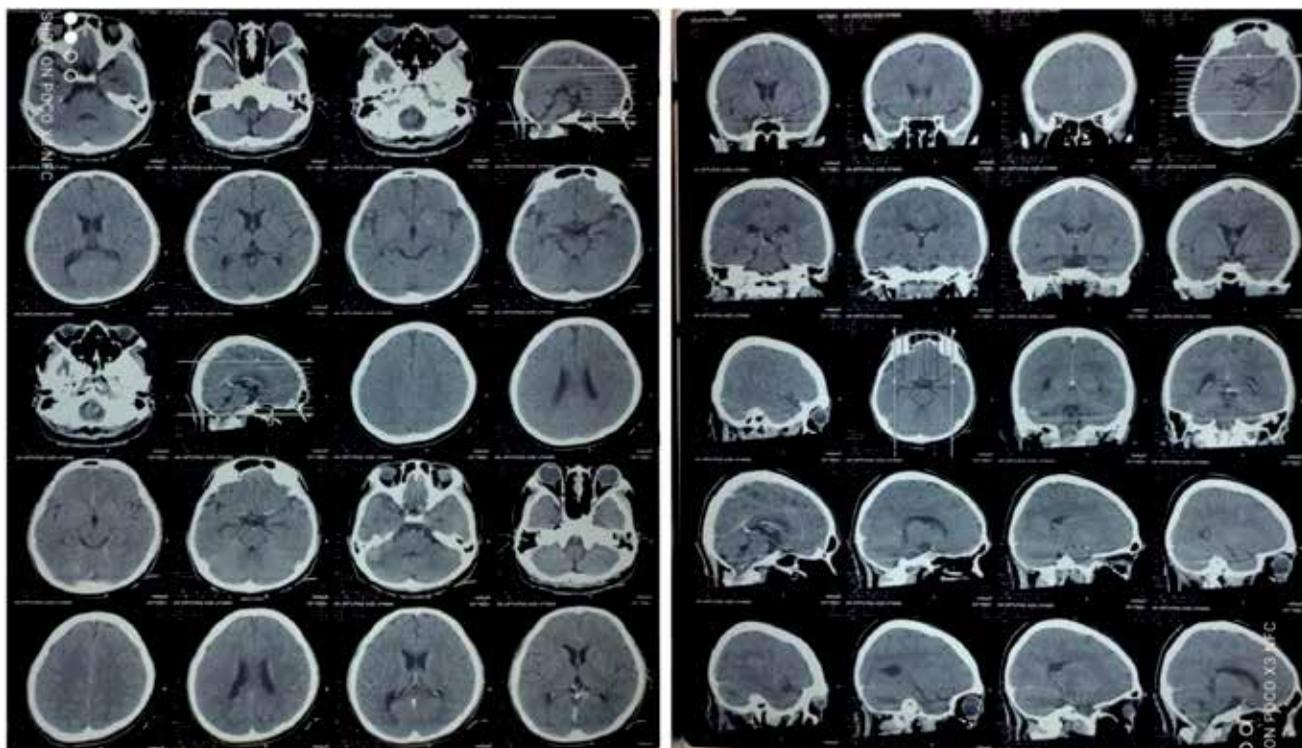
CT scan of the head suggesting a tuberculoma in the cortex-subcortex of the left cerebellar hemisphere with perifocal edema
